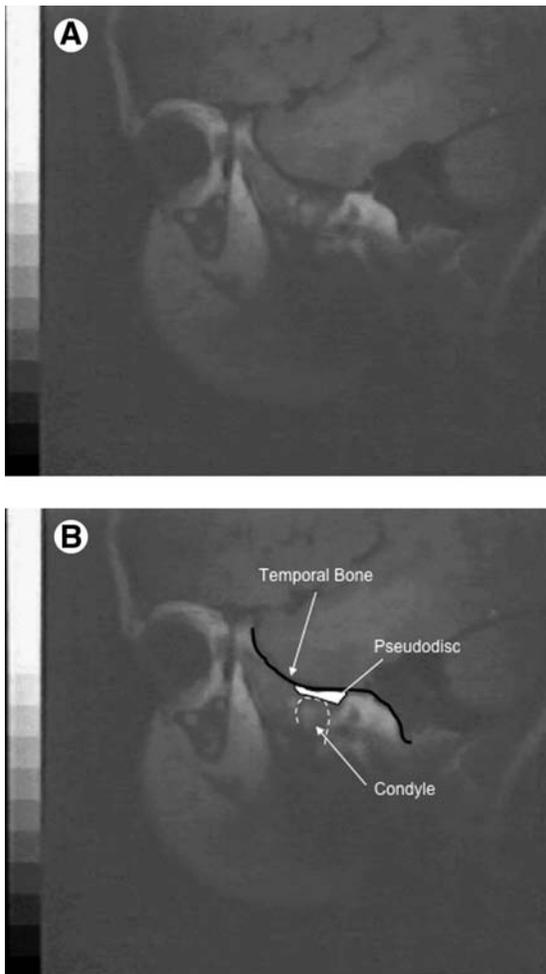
(A) Preoperative MRI of a patient diagnosed with CFM in a closed position showing the morphology of the affected TMJ. The squamous part of the temporal bone has a relatively flat surface and the TMJ does not show clear definition of the articular disk. The temporalis muscle is atrophic and the condyle hypoplastic. There are irregular anterior–posterior translatory movements only during opening and closing, with the absence of hinge axis motion during articulation. (B) Outline and labels for A.
